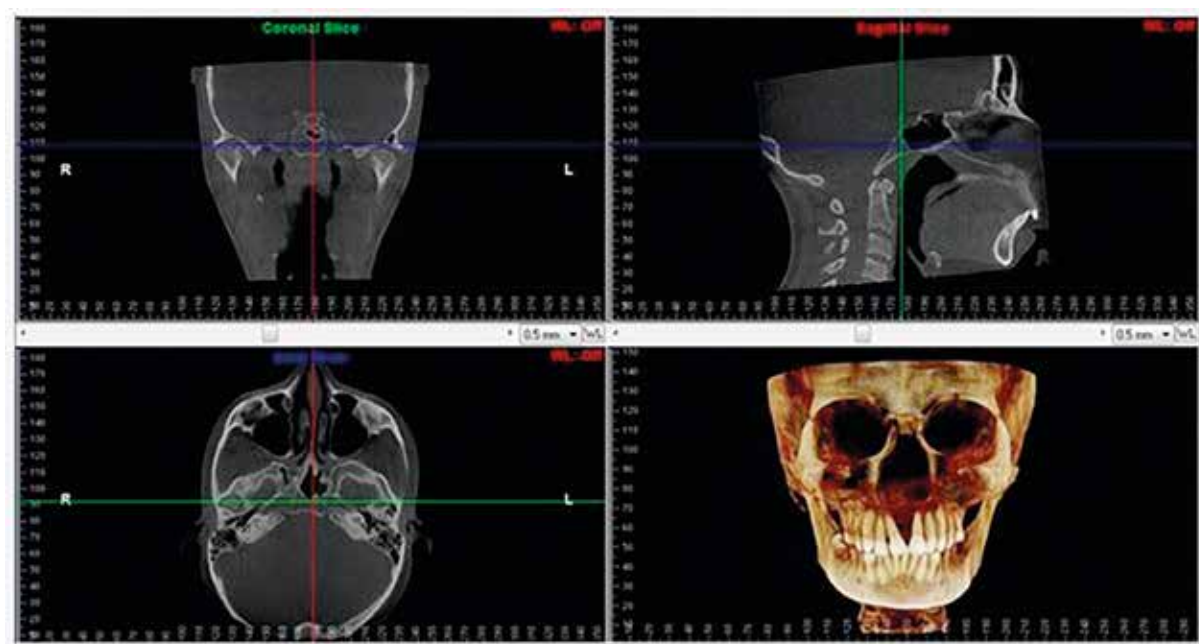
Cone beam computed tomography image orientation in all three planes
